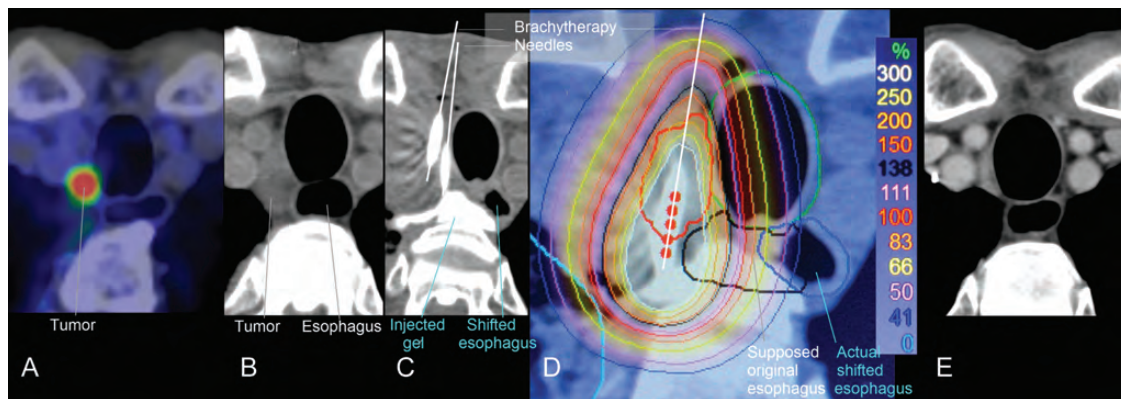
Case 2 with right RNLN recurrence. (A) FDG-PET image obtained 2 months prior to referral shows high FDG uptake in the metastatic RNLN. (B) Unenhanced CT image obtained at the time of referral shows further tumor enlargement during this 2-month period. (C) The esophagus is shifted to the left after gel injection. (D) Dose distribution in the brachytherapy plan. The approximate original position of the esophagus is shown superimposed. Radiation pneumonia is evident in the right lung. (E) CT image obtained 4 months after brachytherapy shows a significant reduction in tumor mass size compared with that shown in (B).
